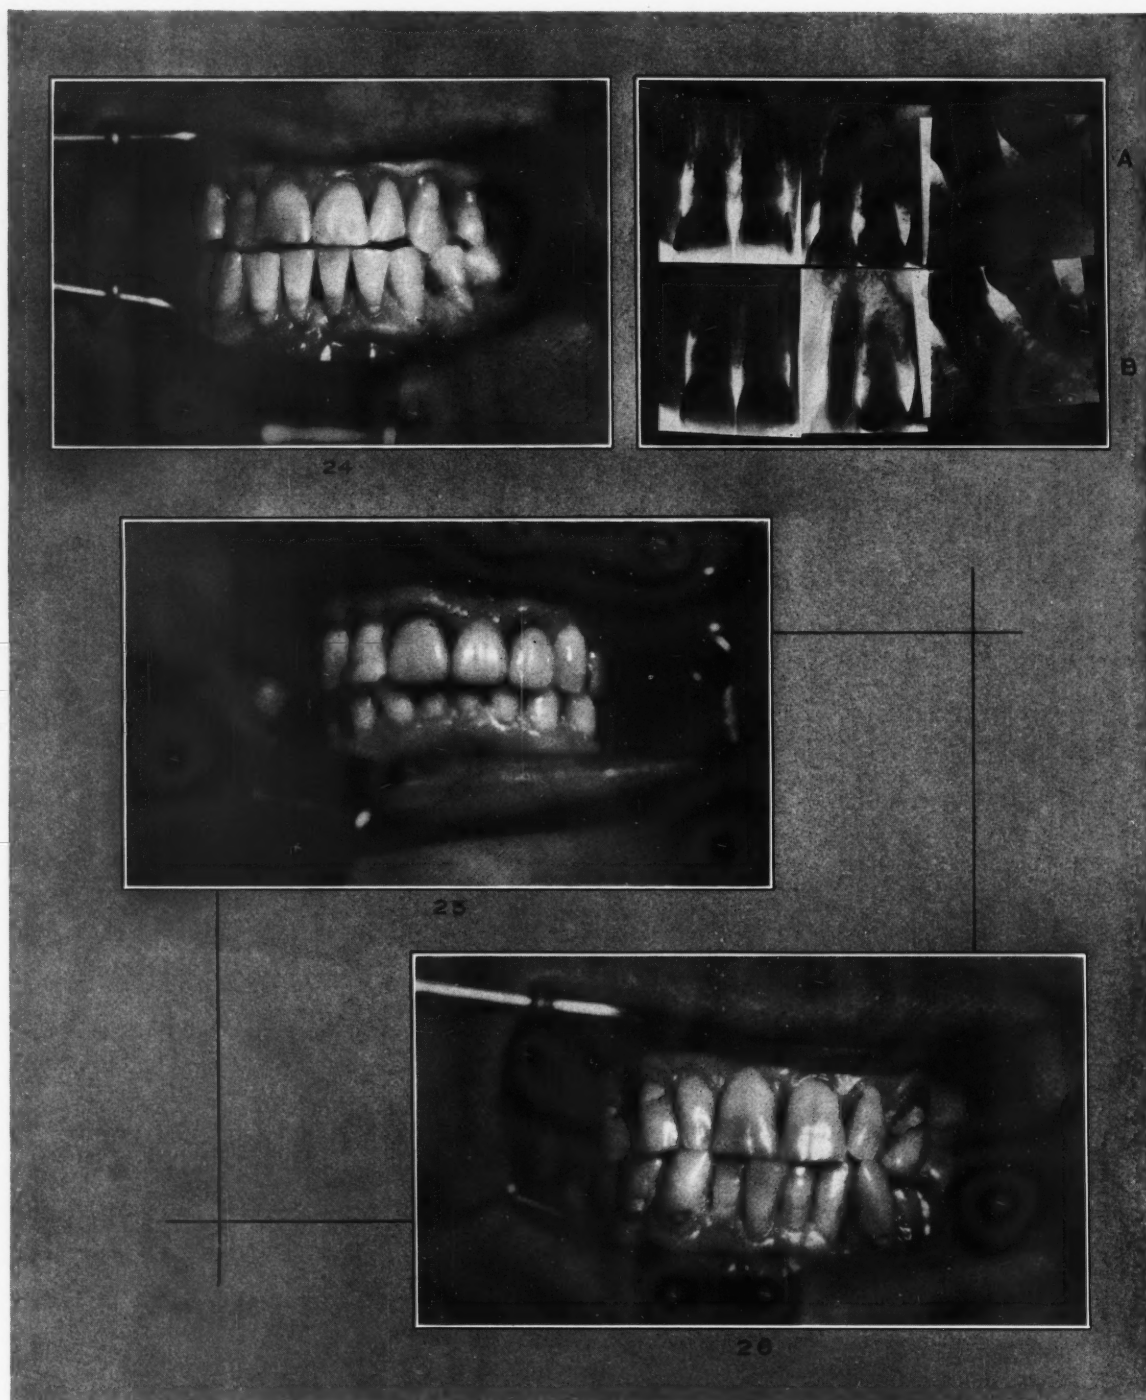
Appearance thirteen months after operation. Roentgenograms show (A), appearance before operation; (B), thirteen months after operation.
